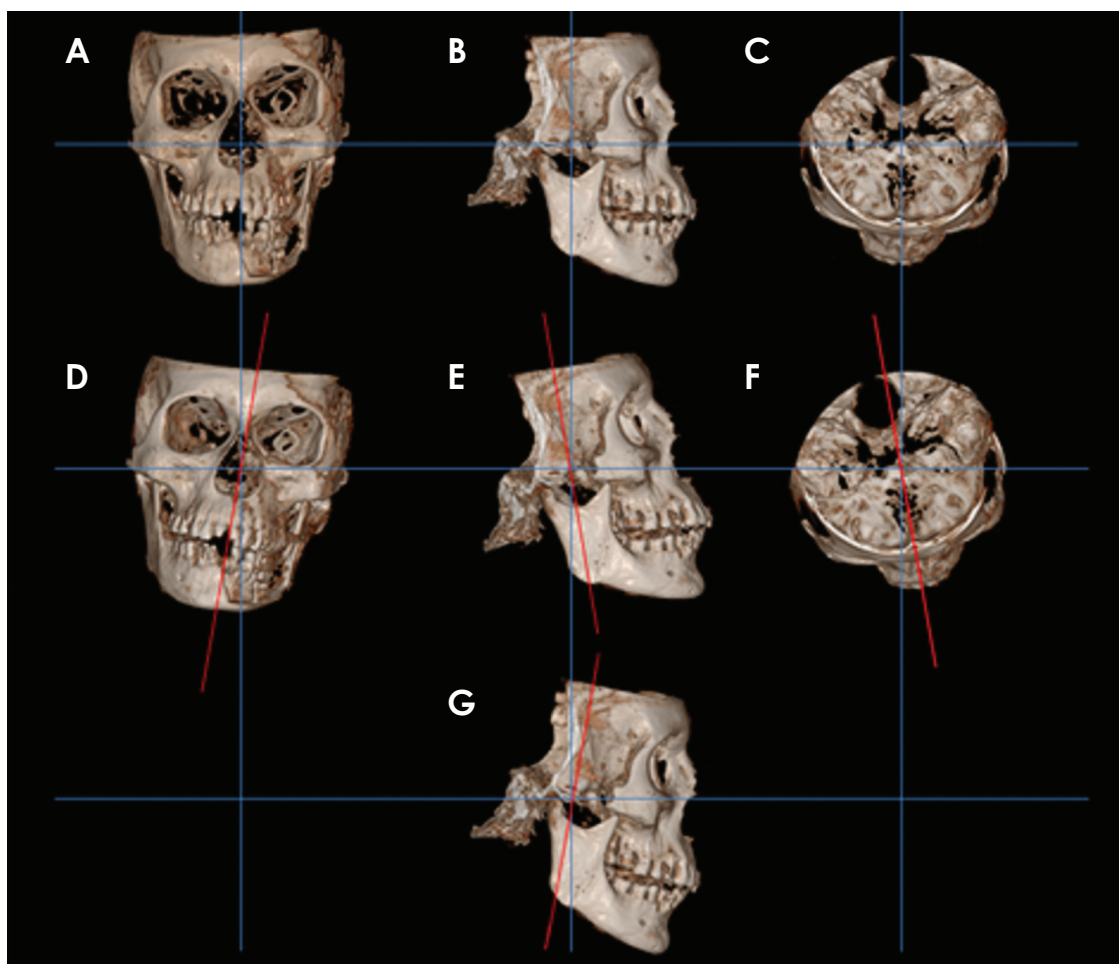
Three-dimensional cone-beam computed tomography images corresponding to 5 head positions. A. Normal position (horizontal plane). B. Normal position (sagittal plane). C. Normal position (axial plane). D. Five-degree leftward tilting. E. Five-degree extension. F. Five-degree leftward rotation. G. Five-degree flexion.
